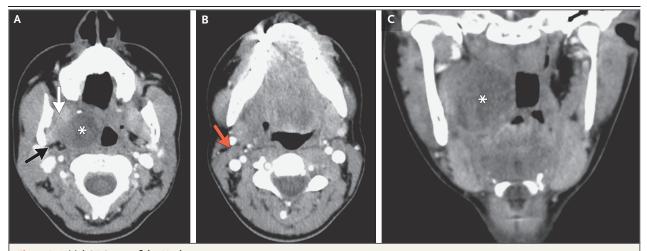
Initial CT Scans of the Neck.
